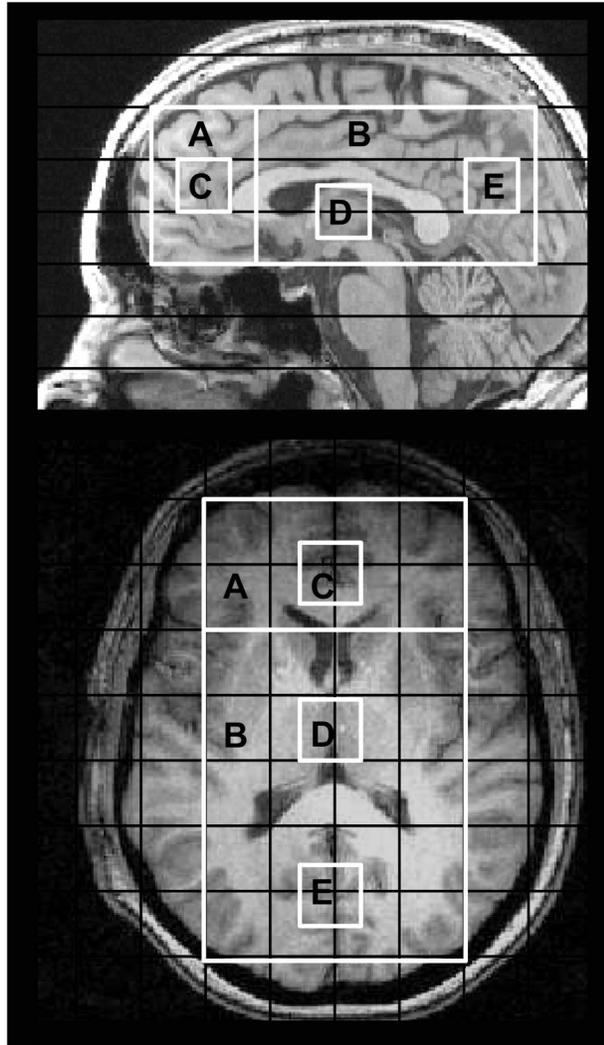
T1-weighted sagittal and axial images depicting the CSI-grid overlay and the various subregions studied. Regions include (A) frontal cortex, (B) whole brain, (C) ACC, (D) thalamus, and (E) POC.
